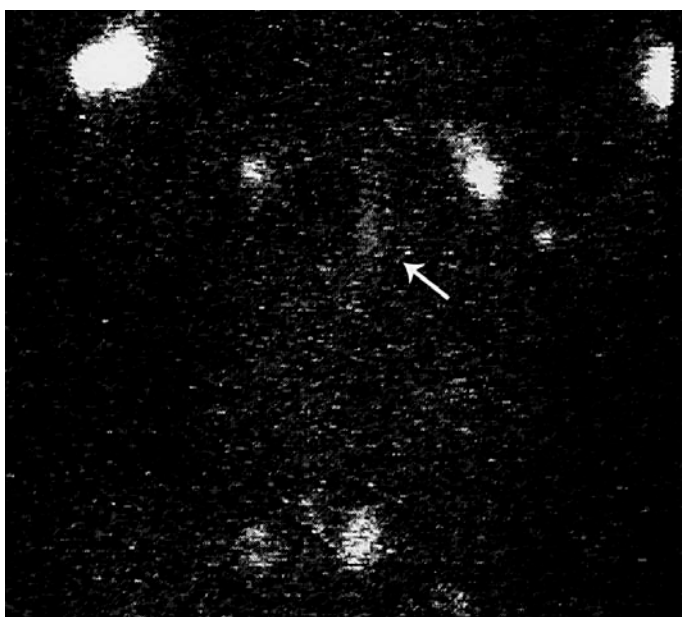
Lymphoscintigraphy.
